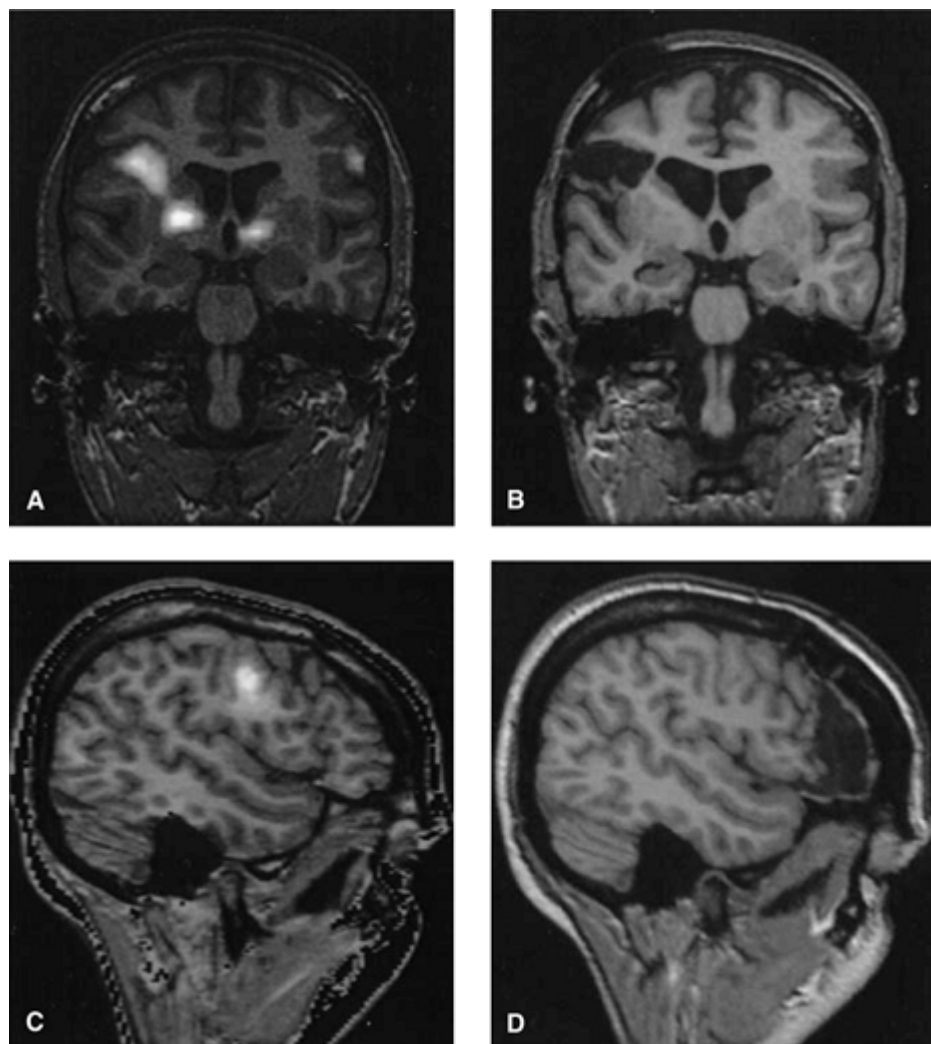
Preoperative subtraction ictal SPECT (single photon emission computed tomography) coregistered to MRI (magnetic resonance imaging) (SISCOM) images (A and C) and postoperative MRI (B and D). A, B: Complete resection of neocortical region underlying SISCOM focus. C, D: Nonresection of neocortical region underlying SISCOM focus. (From O'Brien T, So E, Mullan B, et al. Subtraction peri-ictal SPECT is predictive of extratemporal epilepsy surgery outcome. *Neurology*. 2000;55:1668â€"1677, with permission.) (See the color insert.)
